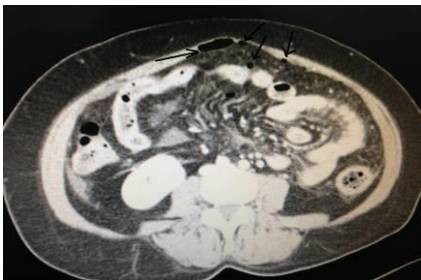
CT of the abdomen and pelvis showing free intra-peritoneal air (black arrows)
